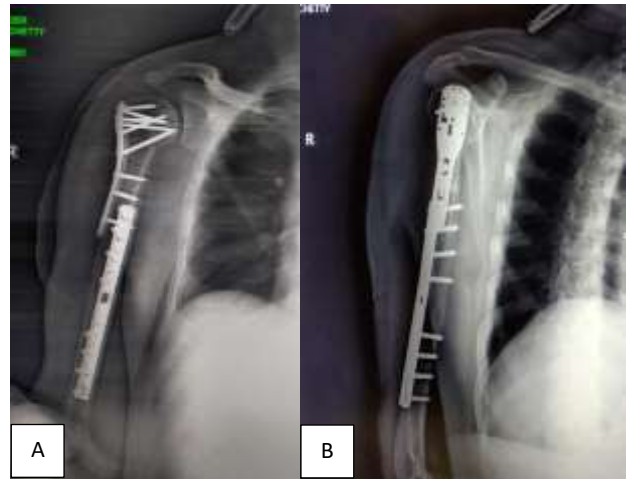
(A and B): Post-operative x-rays.
